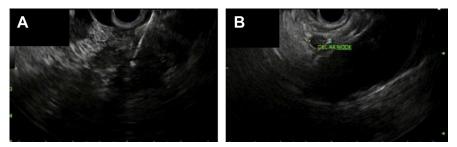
Patient with newly diagnosed pancreatic head mass. (*A*) Endoscopic ultrasound imaging–guided fine-needle aspiration of the irregular, hypoechoic mass was done, cytology confirmed the diagnosis of adenocarcinoma. (*B*) A malignant appearing hypoechoic, round celiac axis lymph node with well-defined margins was also noted.
